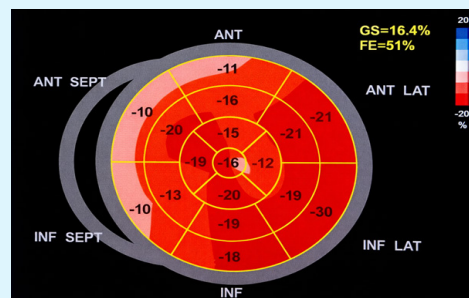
LV GLS assessed by speckle-tracking echocardiography
